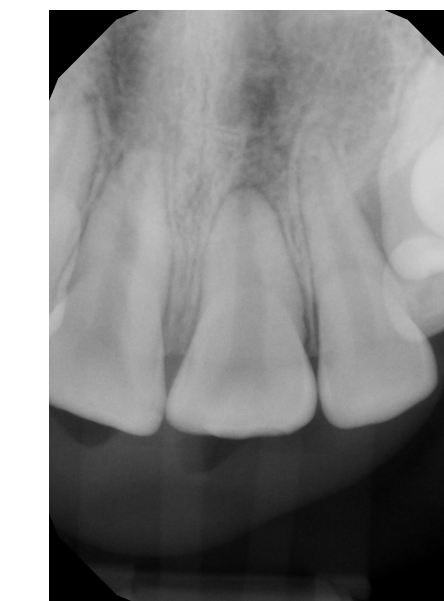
Peri-apical radiograph at recall visit
